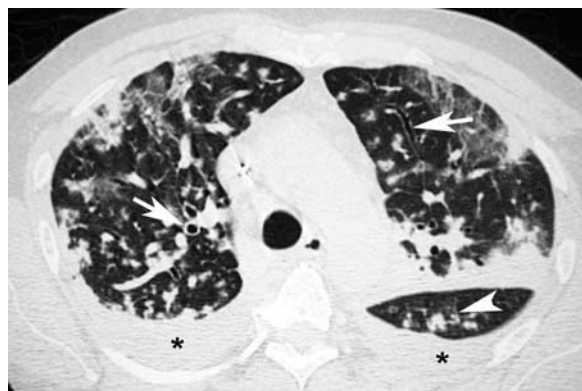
RSV pneumonia. HRCT shows bilateral patchy areas of ground-glass opacities and a dense focal area of consolidation in left upper lobe. Note dilatation and thickening of the bronchial walls (arrows). Branching centrilobular opacities (tree-in-bud pattern) in the superior segment of the left lower lobe (arrow-head) and bilateral pleural effusions (*) are also observed. HRCT indicates high-resolution CT; RSV, respiratory syncytial virus.
